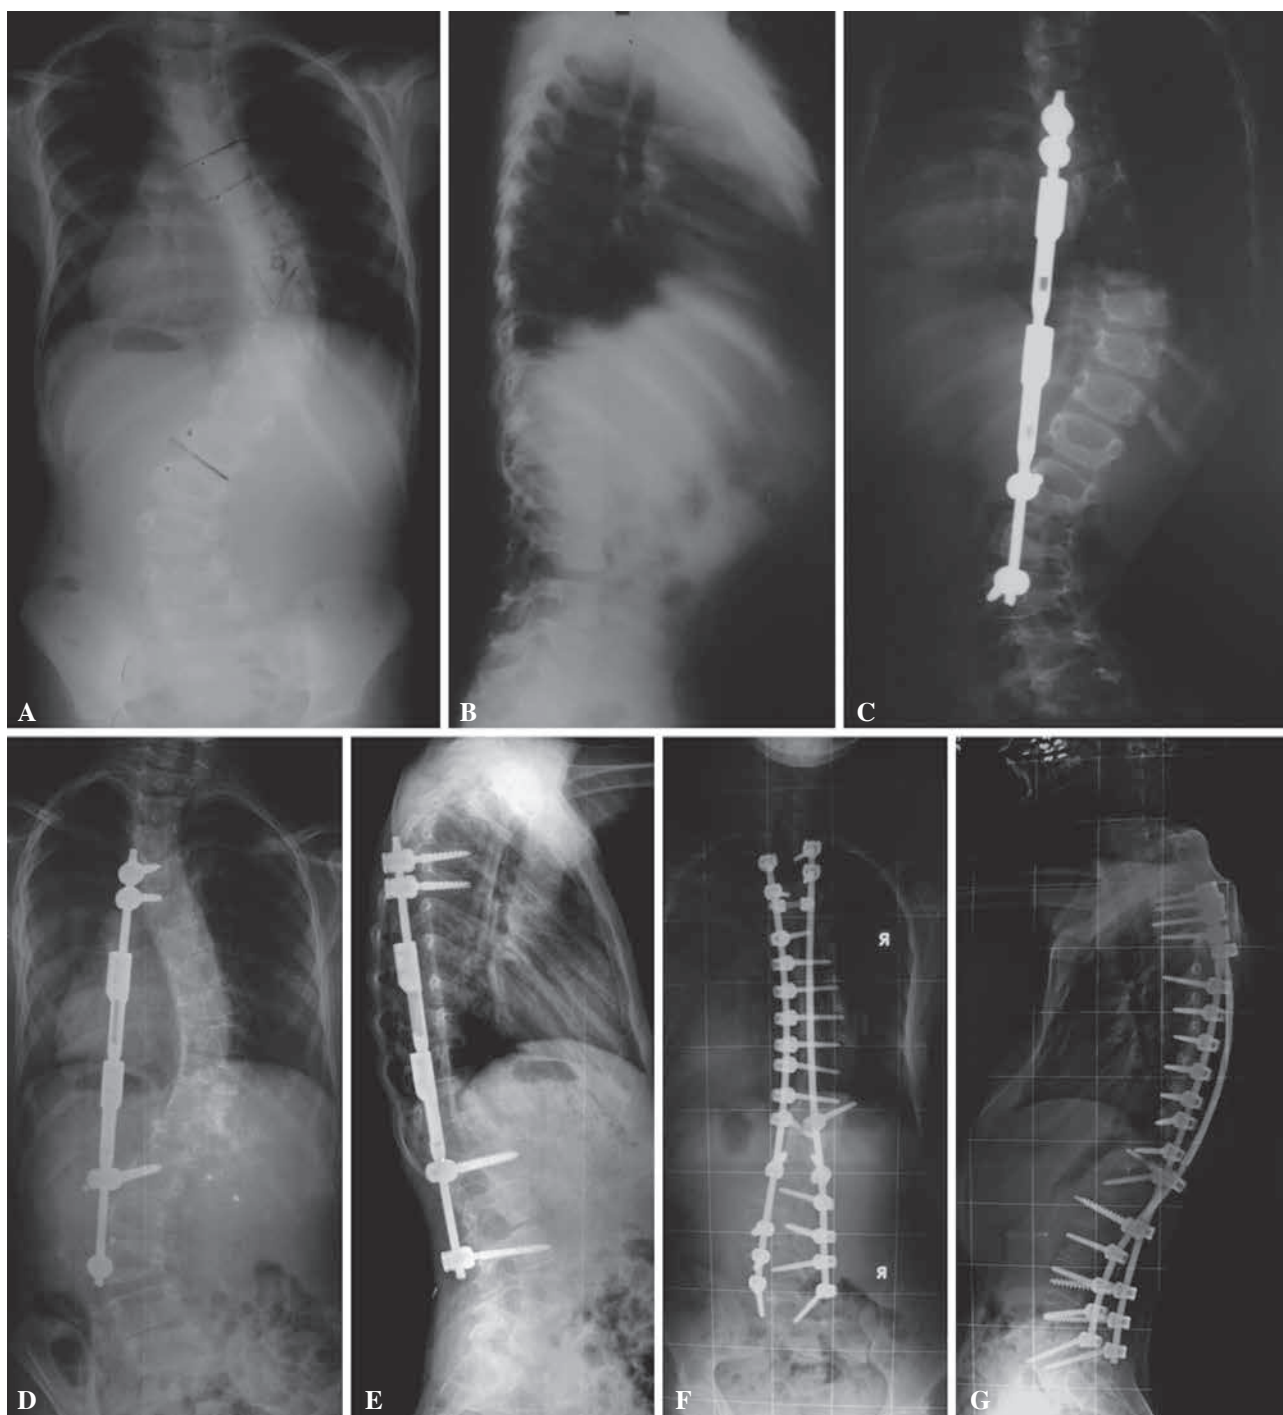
A, Preoperative PA standing spinal radiograph of a 7-year old female with infantile idiopathic scoliosis, with a 62-degree thoracolumbar curve. B, Preoperative lateral radiograph demonstrates normal sagittal alignment C, Postoperative radiograph after insertion of a single growing rod with pedicle screw proximally and distally. The major curve was reduced to 30 degrees. D, PA standing spinal radiograph, taken after routine lengthening procedure showing thoracolumbar curve improvement (40x). E, Lateral radiograph showing acceptable maintenance of sagittal alignment. F, Postoperative PA standing radiograph after fusion surgery showed well balanced spine. G, Lateral radiograph showing acceptable maintenance of the sagittal alignment after fusion surgery.
